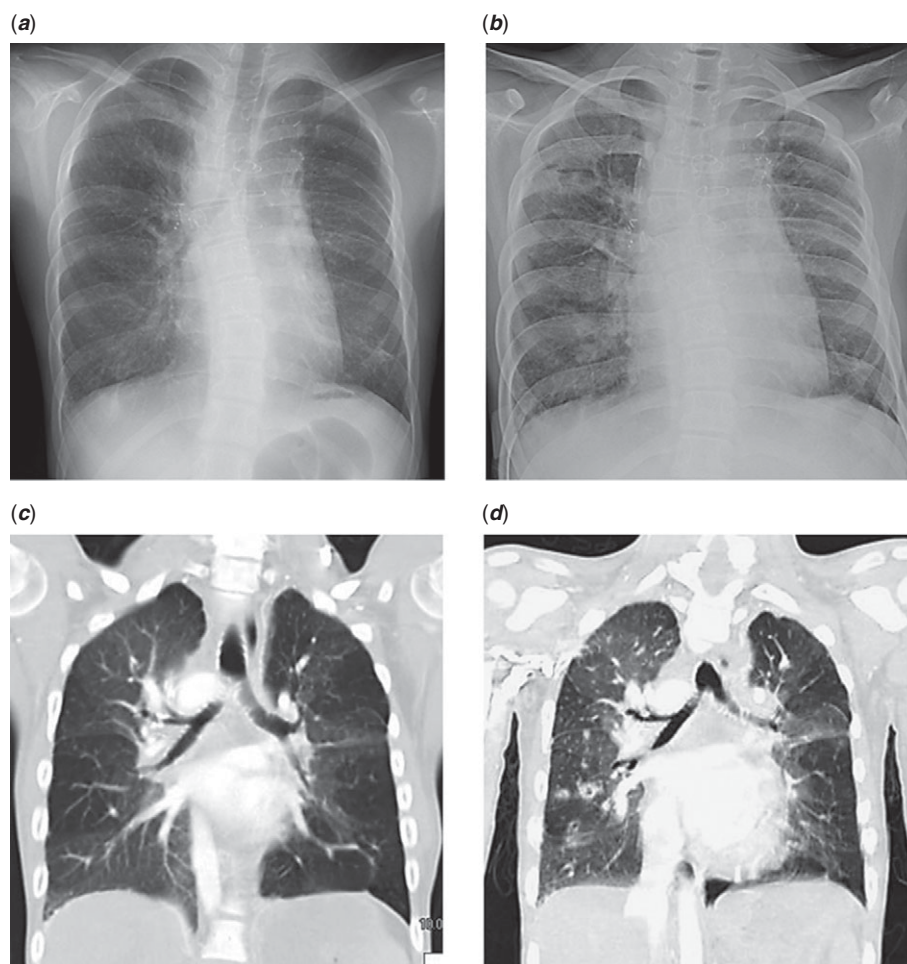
The chest X-ray at admission (a) and three days after admission when the sudden oxygen saturation drop occurred (b). Coronal view of the CT scan performed 3 months before admission (c), and the images after the drop in oxygen saturation (d). Focal opacities and ground-glass attenuation in both lungs are seen.
